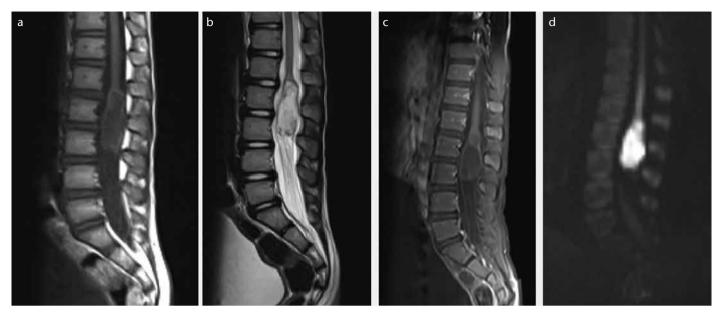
MRI of lumbar spine shows hypointensity on T1WI (a) and hyper-mix signal intensity on T2WI (b), heterogeneous contrast on post-contrast T1WI (c), and limited diffusion on DWI (d). Mass is 4 x1.5 cm in size with lobular contours in the conus medullaris, located intramedullary, and the filum terminale is thick and tense.
